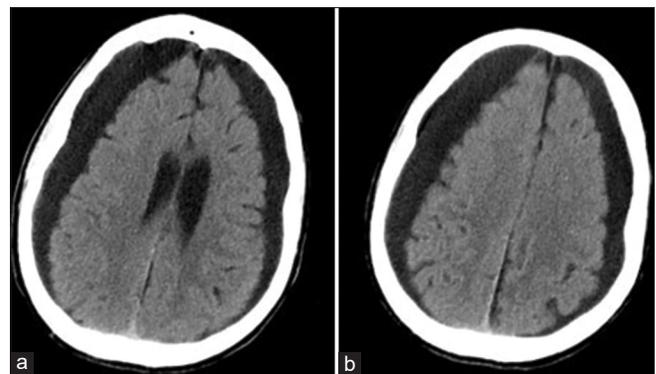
Brain computed tomography scan axial images 3 months after head trauma showed the typical “knife-blade” appearance of the cortical atrophy associated to bilateral hemispheric hygromas 20 mm thick, exerting mild mass effect.
